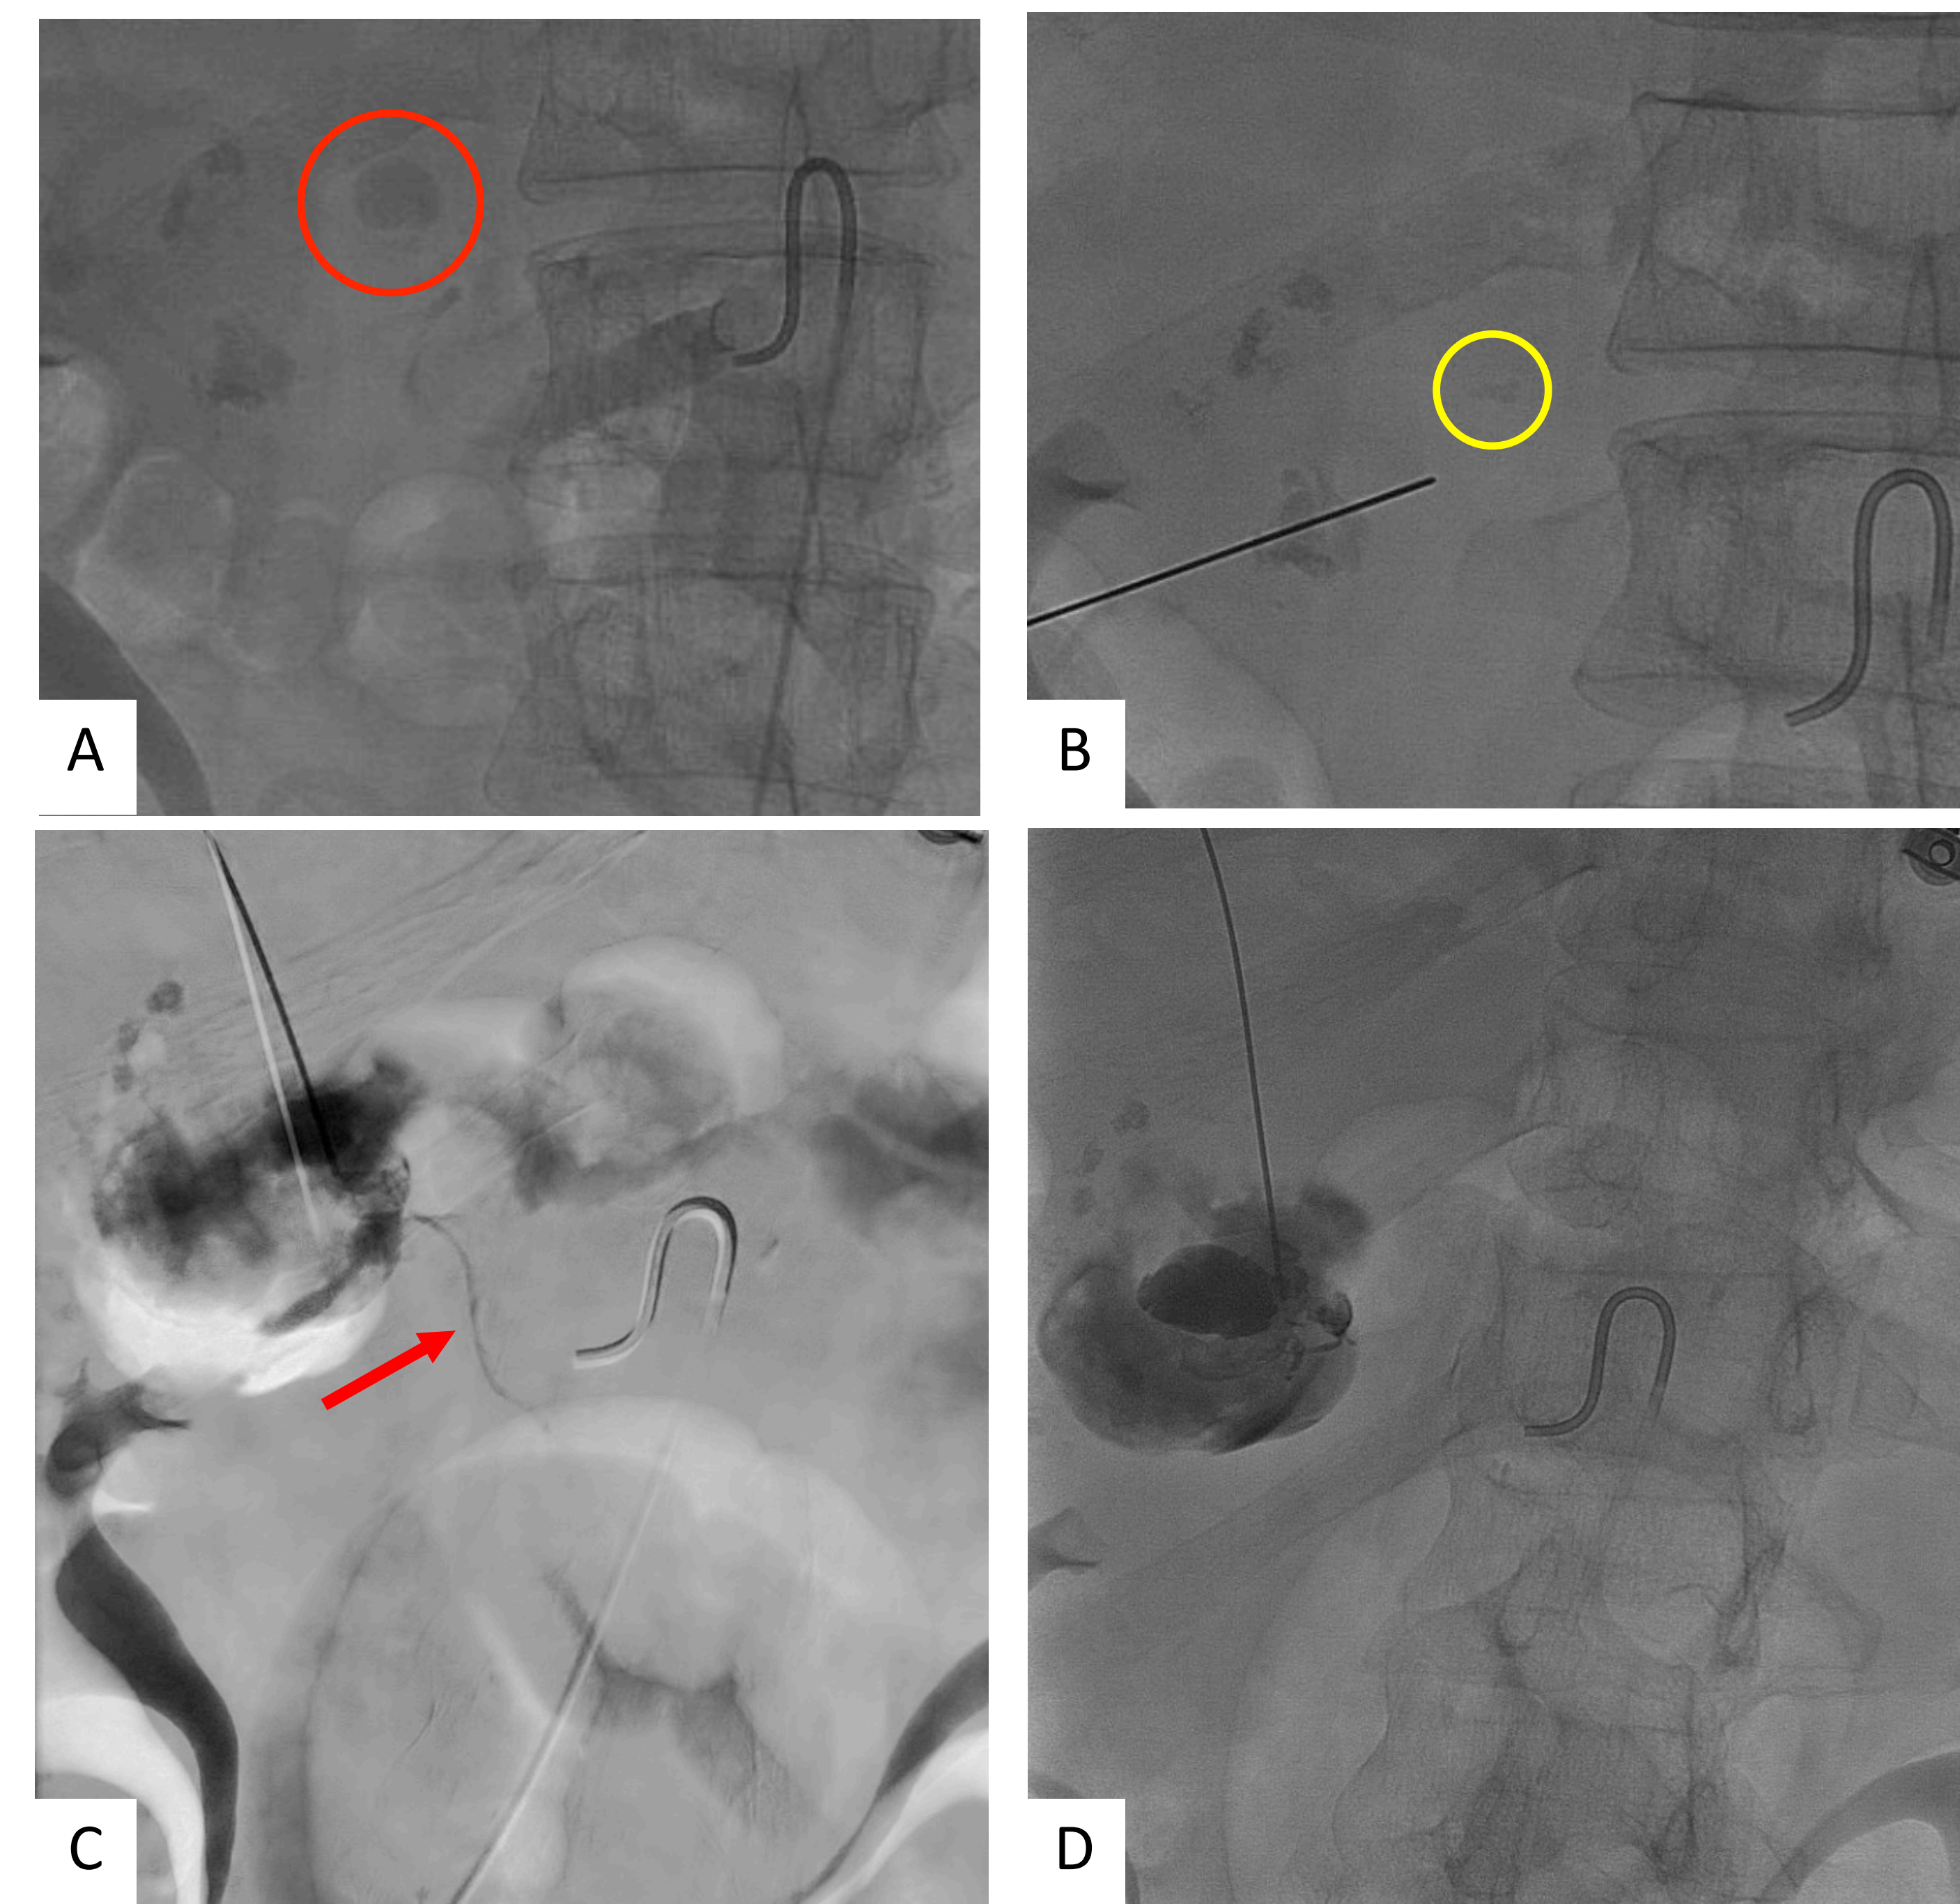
(A) Aortogram demonstrating pseudoaneurysm (red circle) arising directly off of an aortic branch vessel, possibly the right middle adrenal artery. (B) 21-gauge Chiba needle directed toward calcification noted on pre-contrast CT (yellow circle). (C) Confirmation of Chiba needle within the PSA, with thin feeding vessel noted (red arrow). (D) Post-embolization image with Onyx-18 within the PSA.
